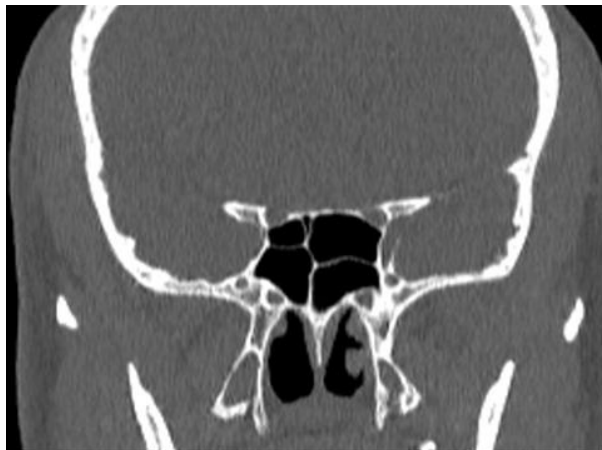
Coronal paranasal CT image of 38-year-old man with bilateral onodi cell (arrows).
